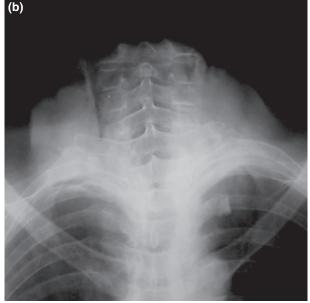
X-ray study. (a) Lateral view of the skull and of the upper cervical spine above the severance plane: air is visible in the meningeal spaces and vessels, and in both lateral ventricles. The skull is intact. The lowest cervical vertebra is the third cervical vertebra. (b) Antero-posterior view of the cervical spine below the severance plane: the highest cervical vertebra is the fourth cervical vertebra. No bone injury of the cervical vertebrae is visible below the severance plane.
